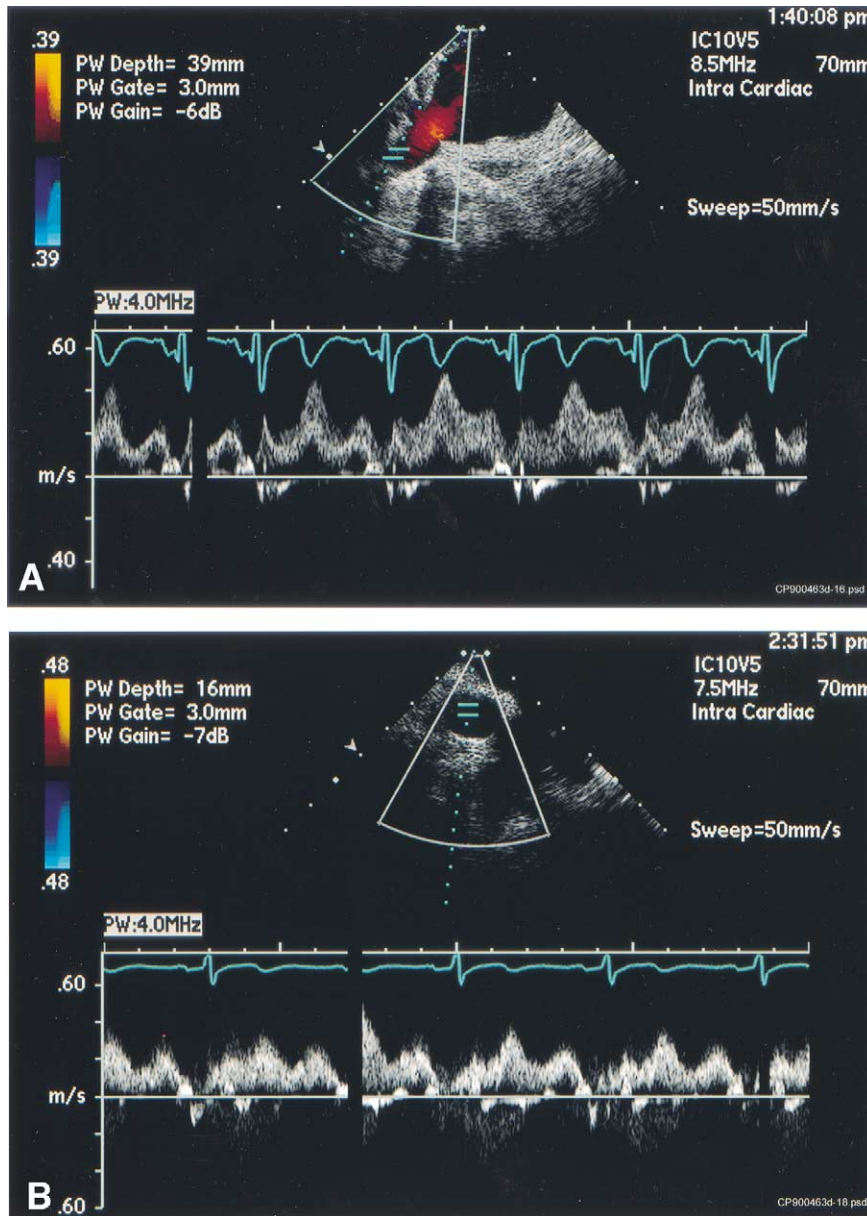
(A) Color flow and spectral Doppler imaging of the right inferior pulmonary vein. (B) Pulsed wave Doppler traces from the orifice of the right superior pulmonary vein. Here the vein orifice is viewed “en fas.”
